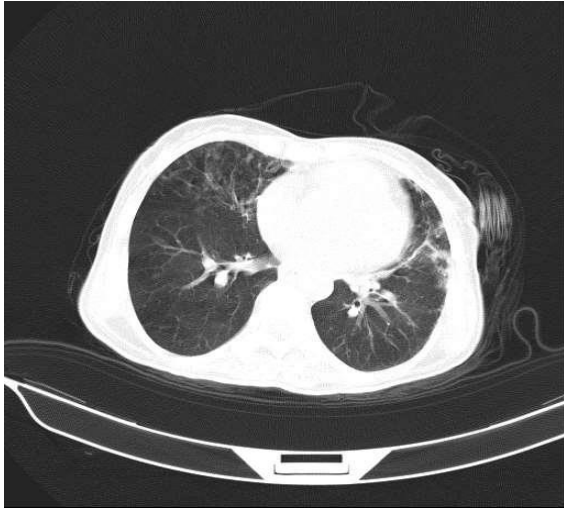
Case No. 3: lung computed tomography (CT) scan of the patient showing typical lung involvements in favor of coronavirus disease 2019 (COVID-19)
